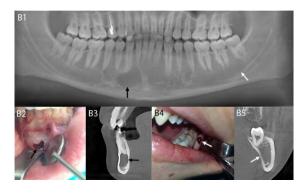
PR (B1), CBCT (B3, B5) and intraoperative (B2, B4) images of Patient No. 10 with bilateral TBCs
